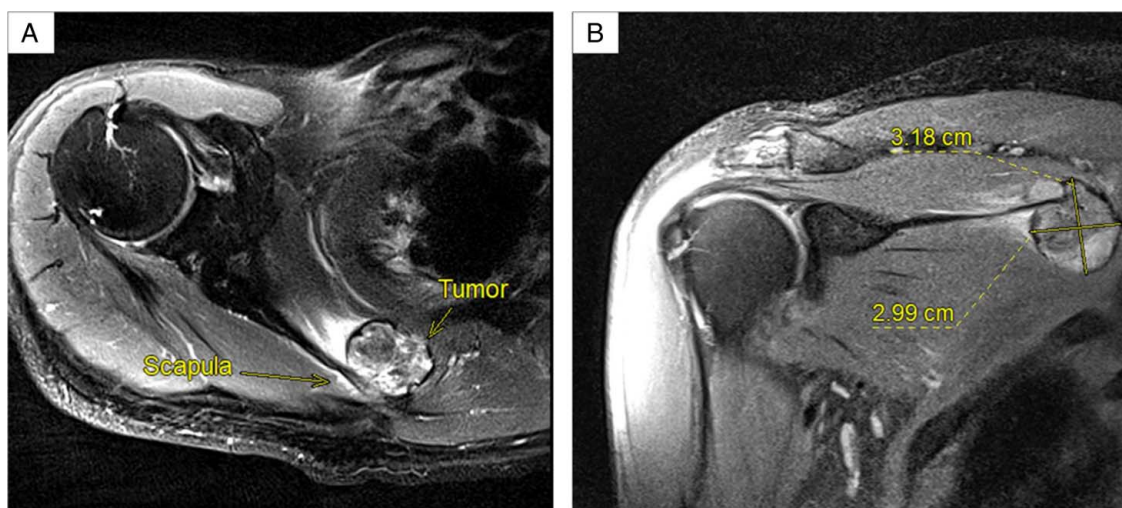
Pretreatment right shoulder MRI. The images showed a mass of 3 × 3 cm in size (B), with invasion of the scapula (A).
